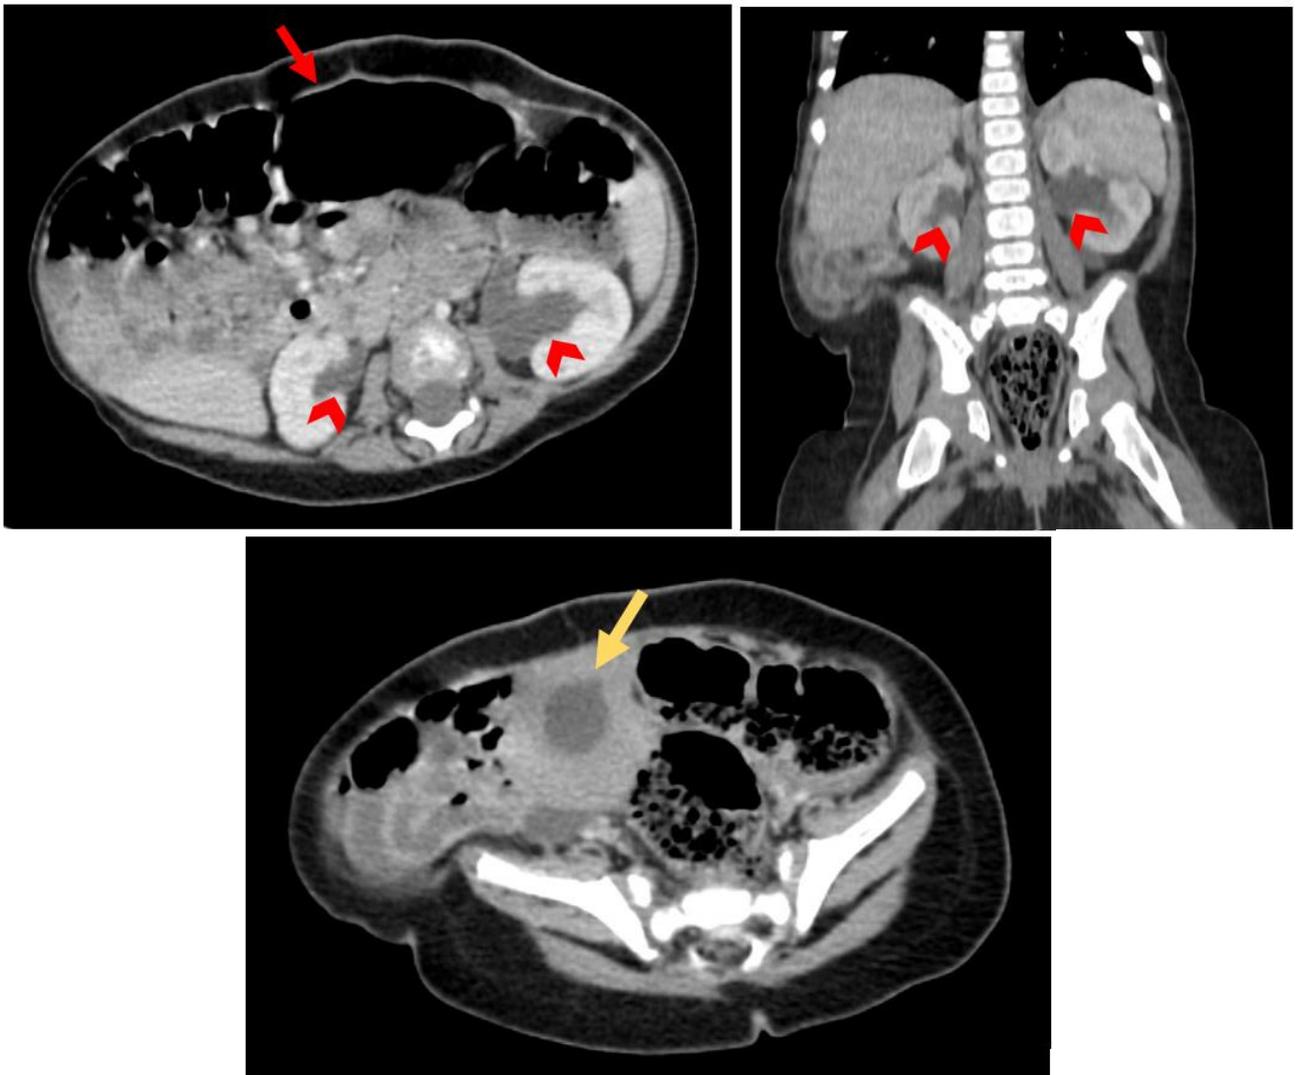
Abdominal CT-scan revealing aplasia of the muscles of the anterior abdominal wall (red arrow), major bilateral ureterohydronephrosis (red head arrows), associated with thickened bladder wall (yellow arrow)
